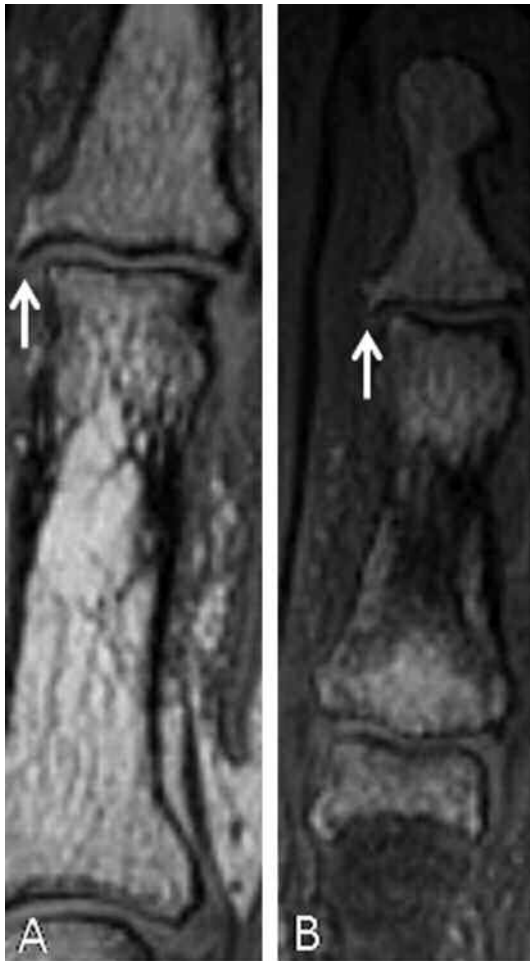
Bone proliferation in PIP (a) and DIP (b) joints. Images are T1-weighted and obtained in the coronal plane.
